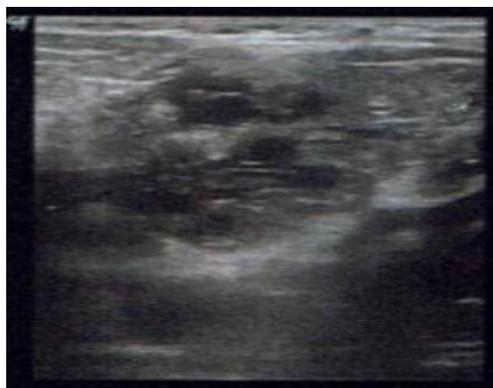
B-mode cervical ultrasound showing a hypoechoic, heterogeneous mass in the left submandibular region, containing multiple anechoic cystic spaces (44 × 25 mm).
